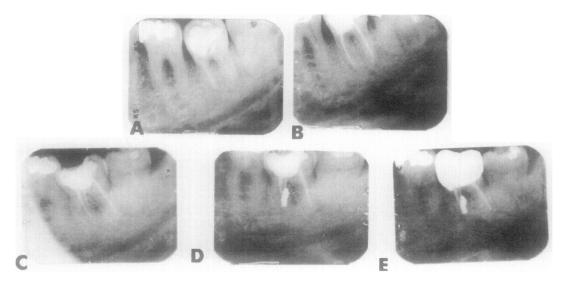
Case 5. Mandibular right second molar of 46-year-old white man. A, Preoperative radiograph showing broken instrument in mesiobuccal canal. Patient has no pain or swelling, but there is apical bone loss. B, Radiogram showing mesiolingual and distal canals after instrumentation and filling with gutta-percha. C, Surgical flap is reflected; apical portion of mesial root is removed to loosen instrument fragment on mesiobuccal canal. Piece of instrument is pushed out of canal through occlusal opening. Radiograph shows mesiobuccal canal having been instrumented and filled with gutta-percha. D, Immediate postoperative surgical radiograph. Apical exits of two mesial canals are connected by groove, slot preparation is made, and retrograde amalgam sealing both mesial canals is placed. E, Recall film approximately 1½ years later showing restored, asymptomatic tooth with apical bone regeneration.
